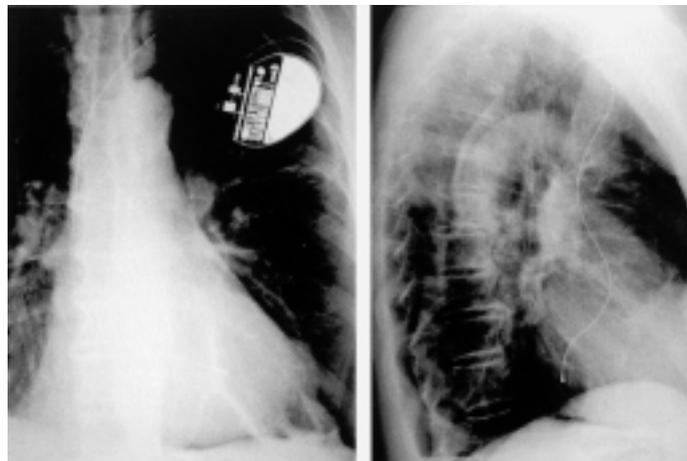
Left panel: postero-anterior chest X-ray. Note the unusually high curvature of the lead as it crosses the atrial septum. Right panel: lateral chest X-ray. The lead appears to be displaced posteriorly and lies in the left atrium.
